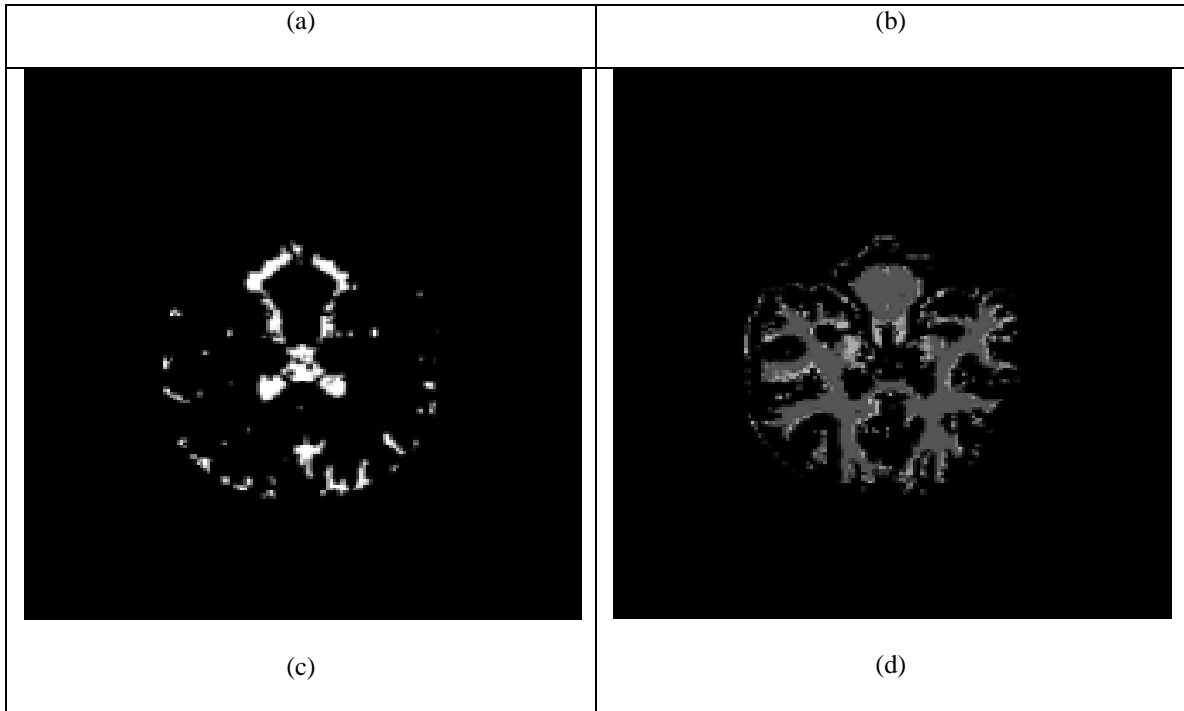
(a)Autistic Female T2-weighted MRI(slice 140), (b) Gray matter, (c) CSF, (d) White matter.
